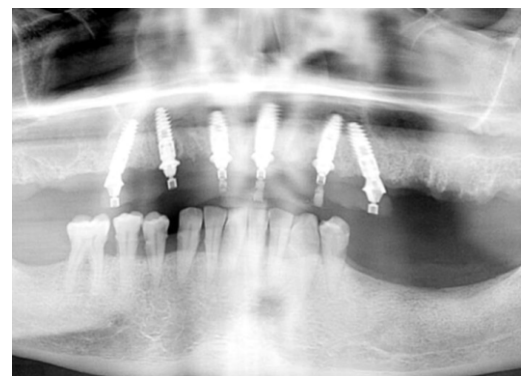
Panoramic radiograph at 3 months showing stable bone levels and stable implant
